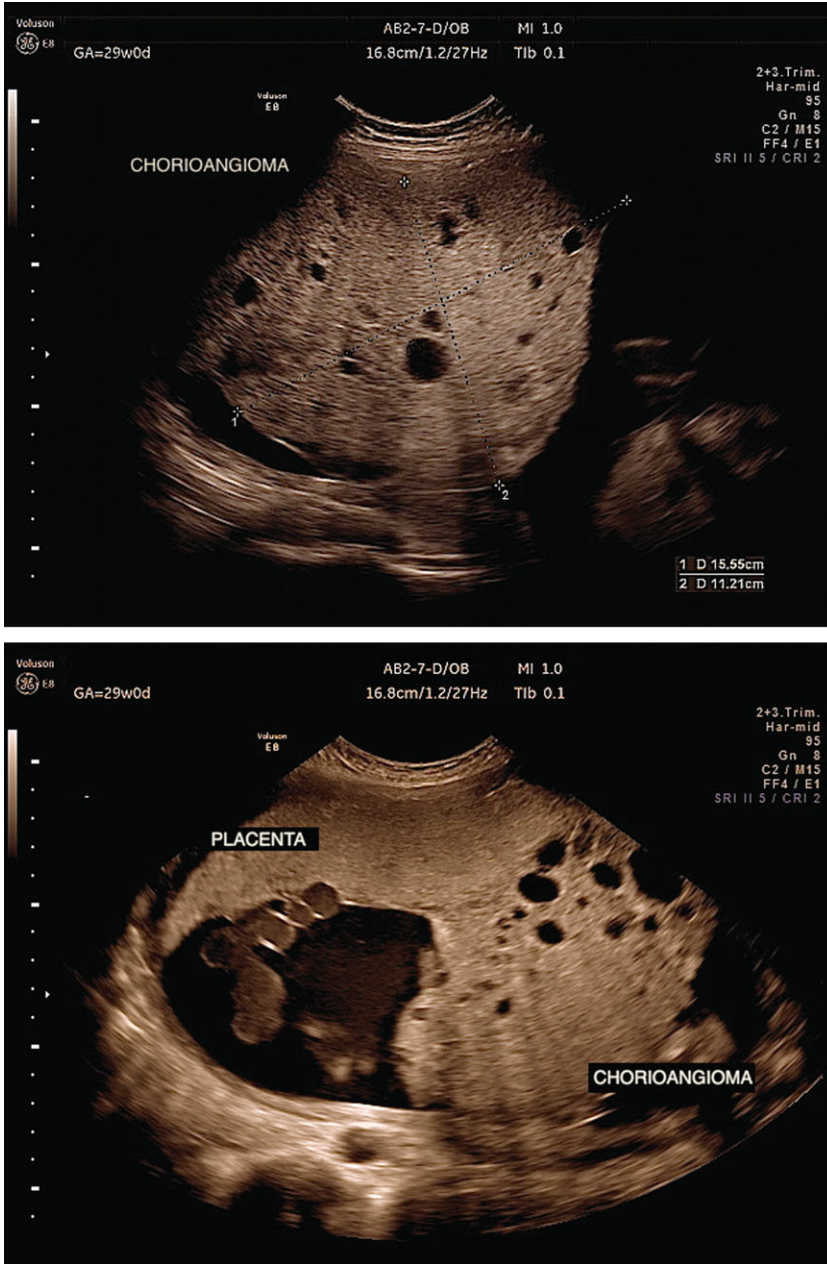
Fetal ultrasound performed at 29 0/7 weeks' gestation demonstrating the giant chorioangioma. The lesion measured 15.6 cm by 11.2 cm by 10.6 cm, arose from the placenta, and occupied approximately half of the amniotic cavity.
